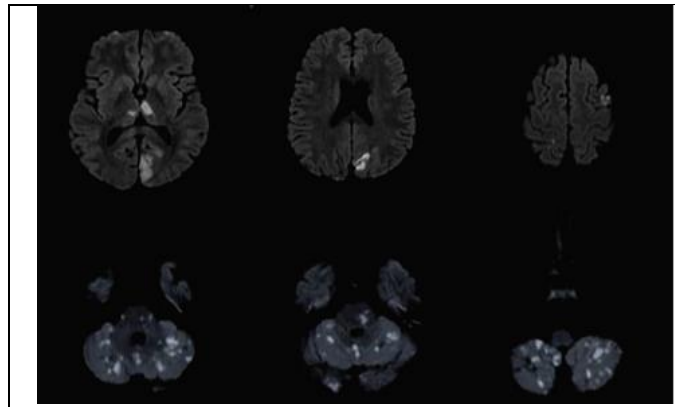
MRI diffusion-weighted scans indicate many distributed sites of diffusion limitation, consistent with acute ischemia.
